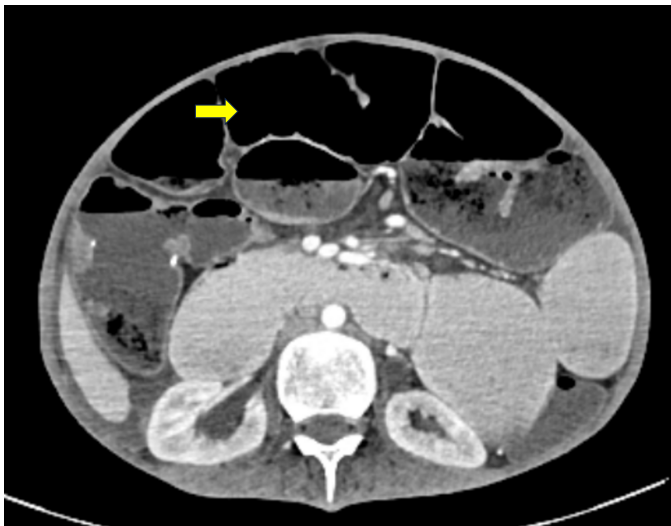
Computed tomography scan showing multiple dilated loops of small bowel with free fluid and air (arrow).
